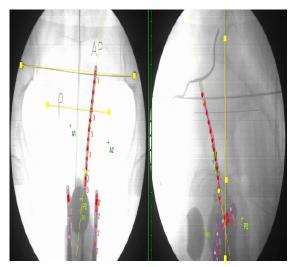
Anterior-posterior (AP) and lateral view (orthogonal radiographs) of the patient
